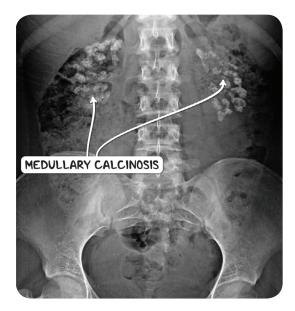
A plain kidney-ureter-bladder (KUB) X-ray demonstrating medullary calcinosis, a complication of renal tubular acidosis.
